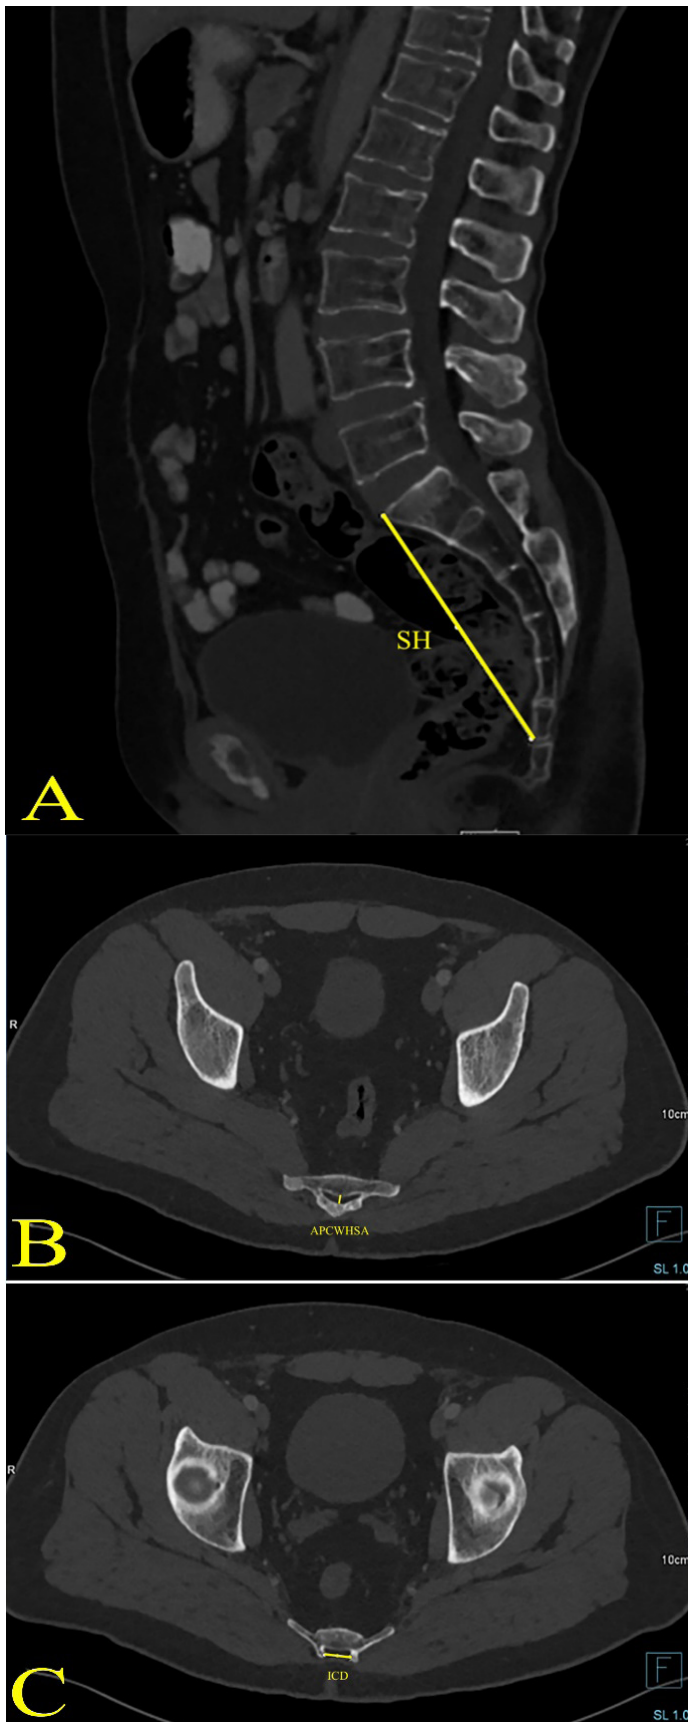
A. SH measurement on sagittal CT, B. APCWHA measurement on axial CT, C. ICD measurement on axial CT
